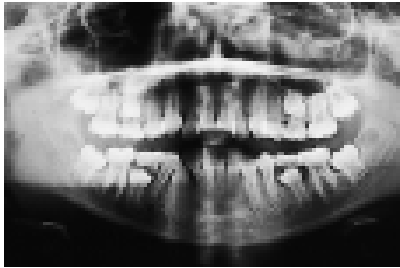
Orthopantomogram of case 1.
